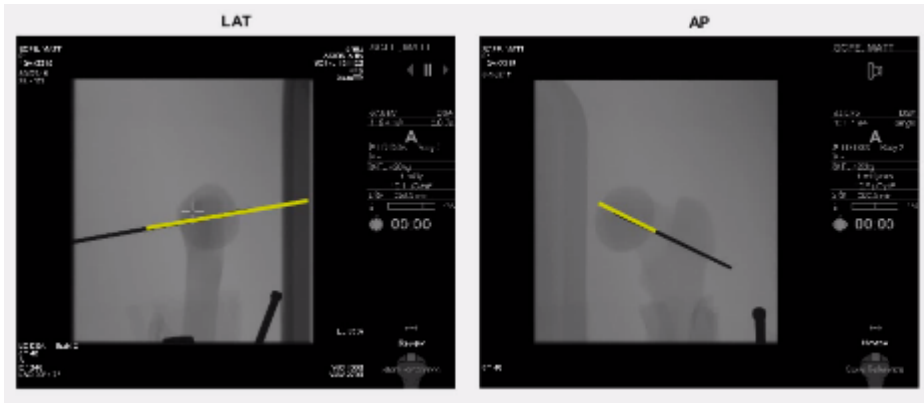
Post x-ray evaluation in Lateral and A-P (yellow line is the trajectory before drilling)
